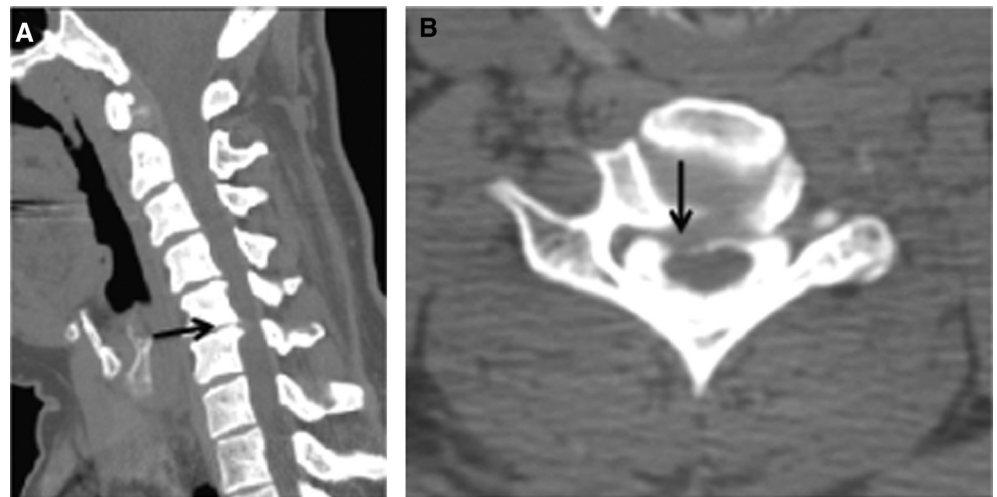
Preoperative computed tomography myelogram in a 39-year-old woman presenting with cervical radiculopathy and myelopathy. Lateral (A) and axial (B) C-spine computed tomographic myelogram at the level of C5-6 showing a para-central disk protrusion resulting in significant central canal and right greater than left neuroforaminal stenosis.
